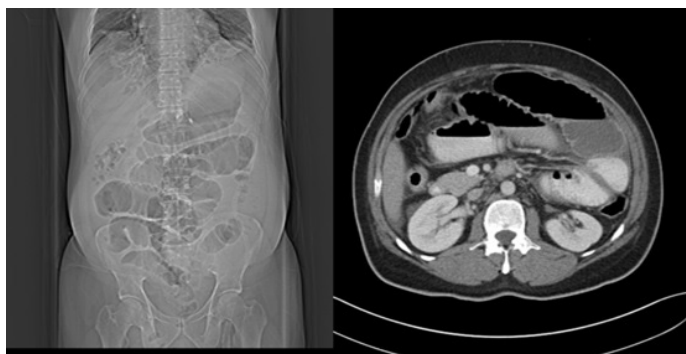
Dilated jejunal and proximal ileal loops seen in abdominal CT-Scan with multiple air-fluid levels.
